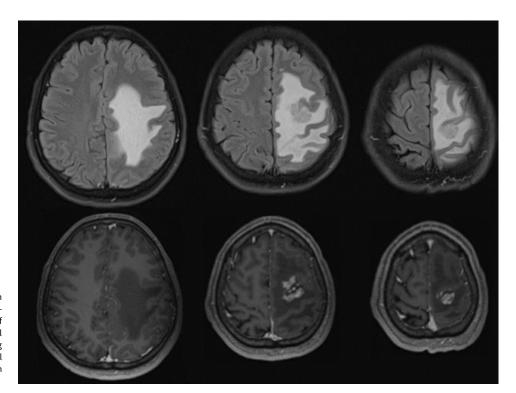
Row 1: Fluid attenuated inversion recovery (FLAIR) axial MRI. Row 2: T1 postgadolinium contrast axial MRI. Presence of hyperintense signal abnormalities with cortical and subcortical involvement. Patchy enhancing foci along the cortex and adjacent subcortical white matter involving the left motor gyrus in the posterior left frontal lobe.
